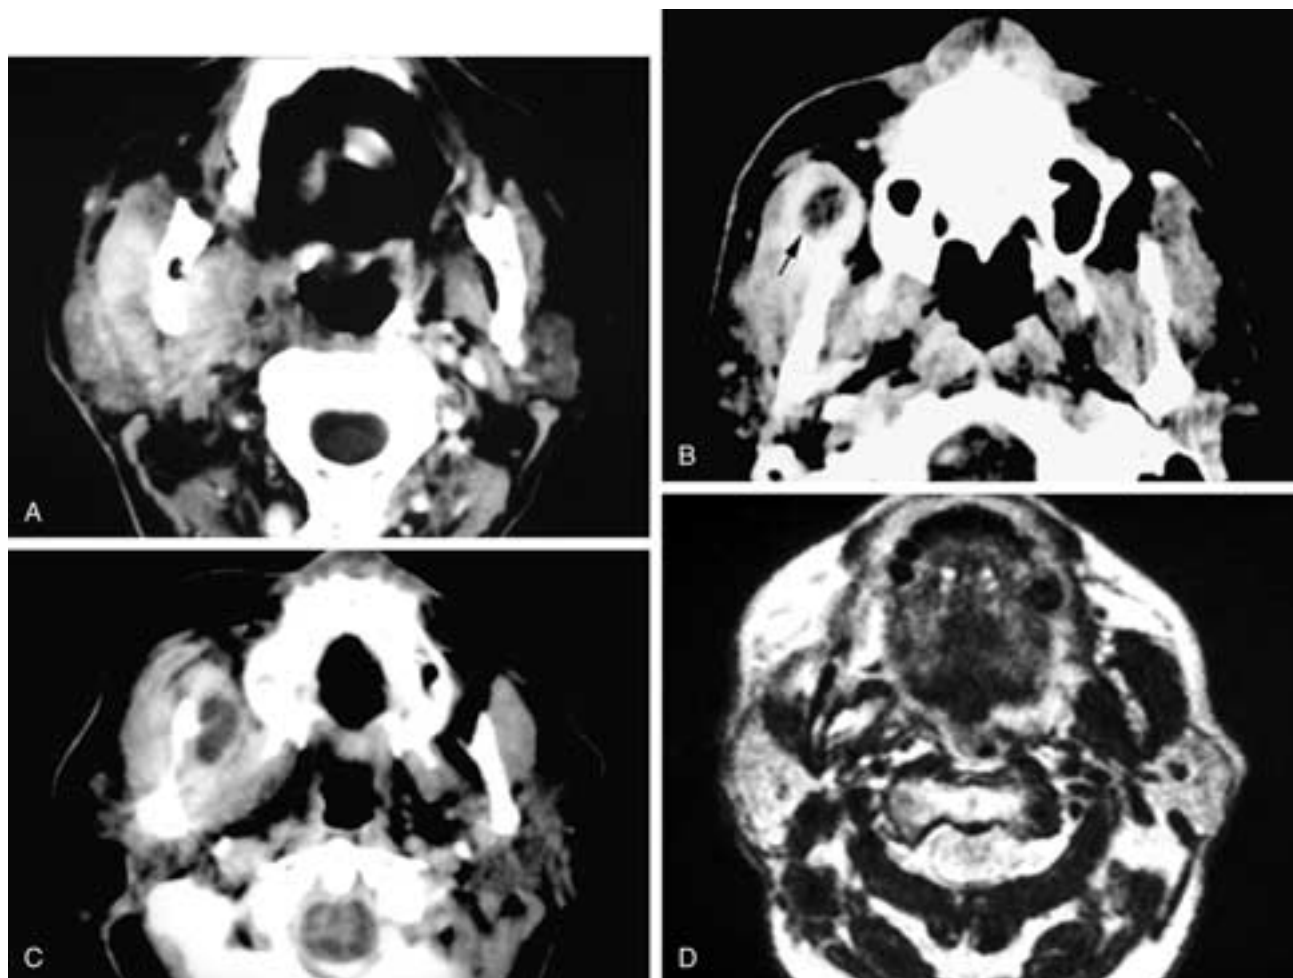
Axial contrast-enhanced CT scans show (A) enlargement and enhancement of the right masticator space muscles, with effacement of the adjacent fat planes including the fat in the right prestyloid compartment of the parapharyngeal space. There is also enhancement of the right parotid gland representing a secondary parotitis. This was an acute cellulitis of the masticator space. In B, there is swelling and enhancement of the right masseter muscle, with a low-attenuation abscess (arrow) anteriorly within the muscle. There is also enhancement of the medial pterygoid muscle in this patient with a masticator cellulitis and abscess. There is virtually no effacement of the adjacent fat planes. In C, there is a right masticator space cellulitis and abscess, with virtually no effacement of the adjacent fat planes. In D, an axial T2-weighted MR image shows the right masticator space muscle to have high signal intensity (compared to that of the normal left masticator muscles). This patient had a right masticator space cellulitis.
